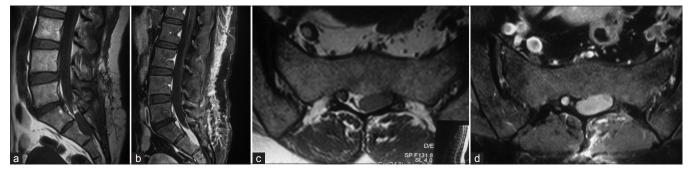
(a) Sagittal TI-W MRI without contrast injection, before the first surgery. An extradural hyposignal lesion is observed at SI-S3 level, which was neglected in the first intervention. (b) Sagittal TI MRI with contrast from the lumbosacral region after the first operation. Homogenous enhancement of the lesion is observed. (c and d) Axial TI MRI views of the lesion with and without contrast, after the first operation
